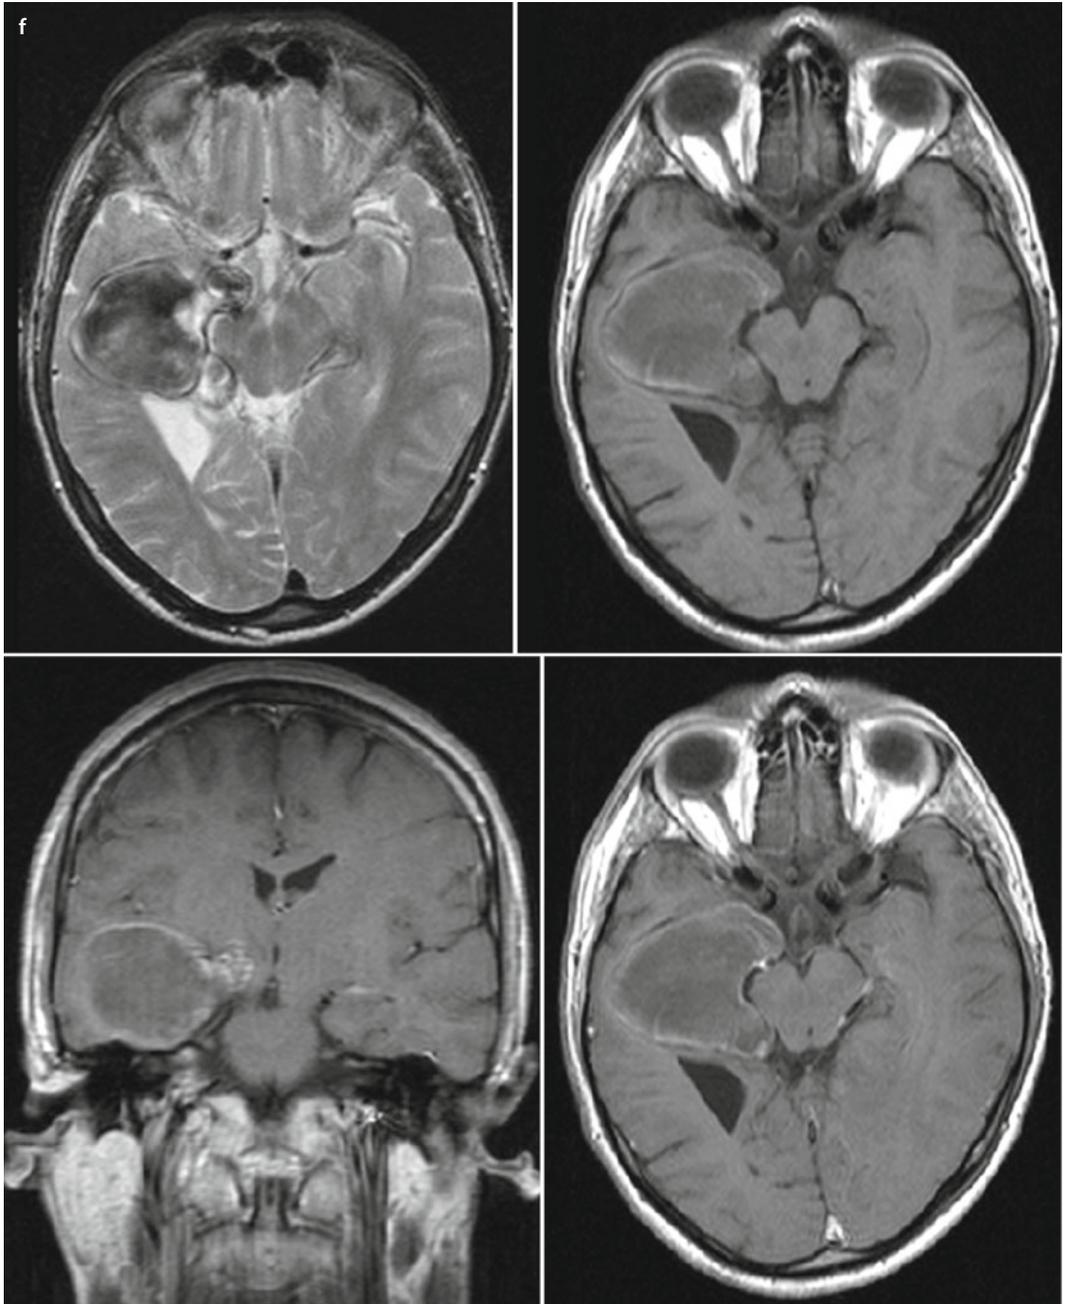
A 32-year-old man presented with headache and diaphoresis. (a) NECT reveals a hyperdense mass in the right ambient cistern (*arrow*). In 2007, cerebral DSA shows a right PCA (P2 and P3 segments) dolichoectatic fusiform enlargement. (b) After a period of 6 years, the patient presented with worsening symptoms; a repeat MRI on 2013 reveals a heterogeneous predominantly hypointense mass with peri-lesional vasogenic edema in the right deep temporal region adjacent to the mesencephalon probably along the choroidal fissure. Postcontrast MRI images show serpentine enhancing vessels within the heterogeneous mass
